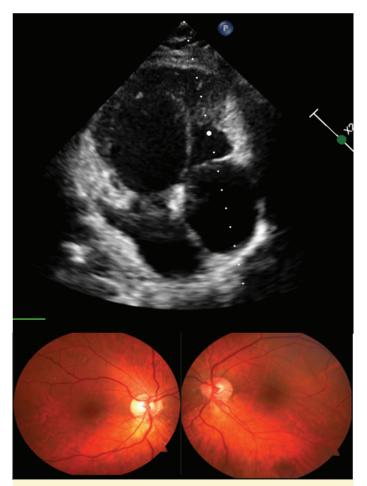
Echocardiography revealing a highly echogenic, thickened pericardium attached to the posterior left atrium and left ventricle. Fundoscopy shows bilateral yellow discoloration and yellow dots in the mid-periphery of the retina.
